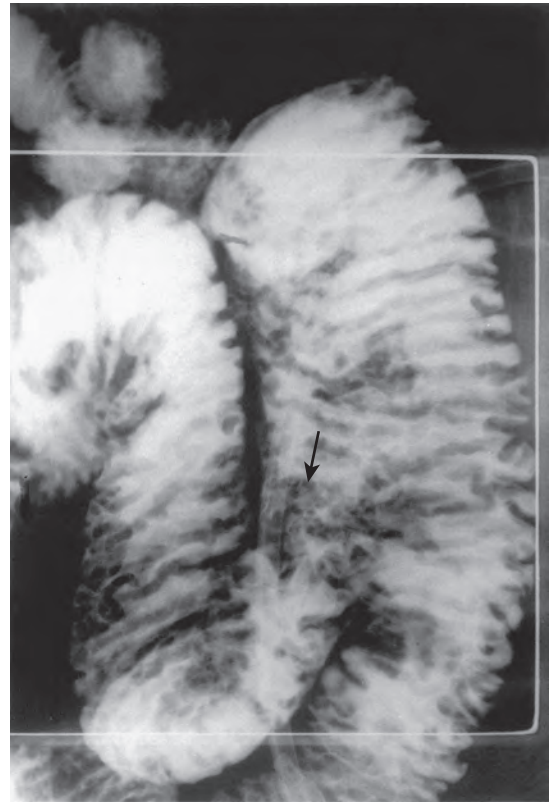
Lymphangiectasia. This spot radiograph from enteroclysis shows mildly thickened, irregular folds. Tiny mucosal nodules (arrow) are seen in one region because of enlarged, bulbous villi.
